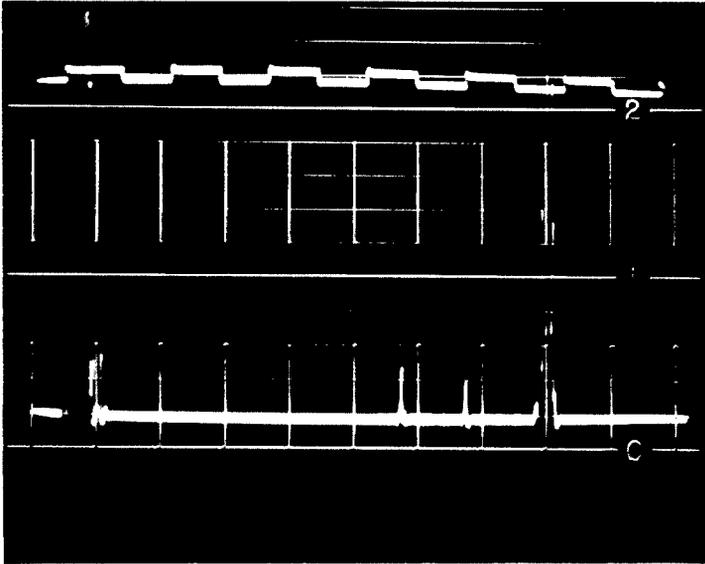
Ultrasonogram Prior to Intra-Arterial Injection in Rabbit No. 2. Note Similarity to Figure 18.
